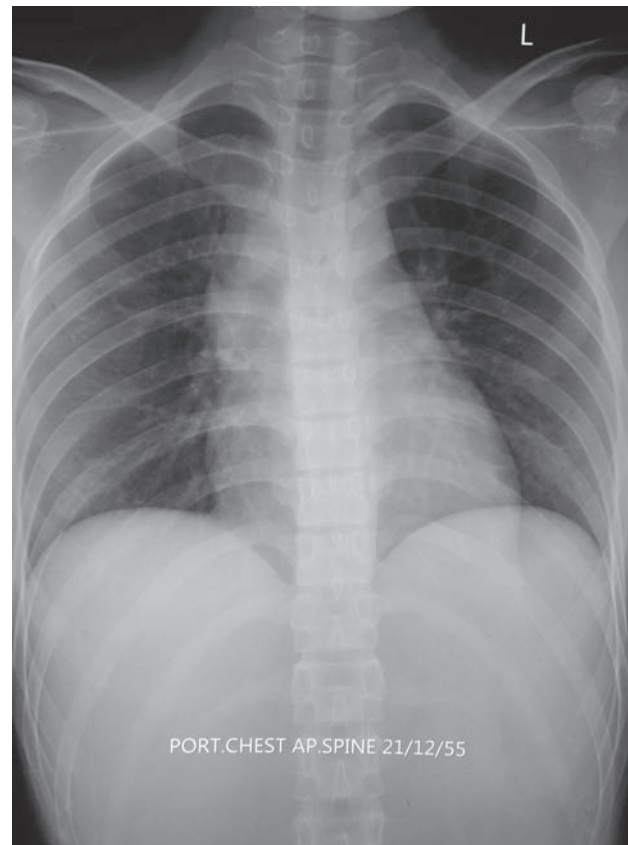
Chest X-ray showed slightly widening mediastinum.
